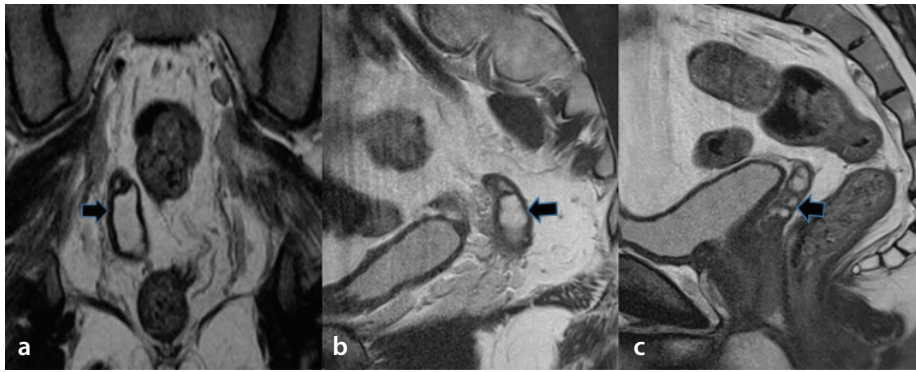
A 27-year-old patient with bilateral vasal agenesis and azoospermia. The T2-weighted coronal (a) and sagittal (b) images show the intra-abdominal part of the right vas deferens dilatation (black arrows). The T2-weighted sagittal image (c) shows a normal ipsilateral seminal vesicle (black arrow).
